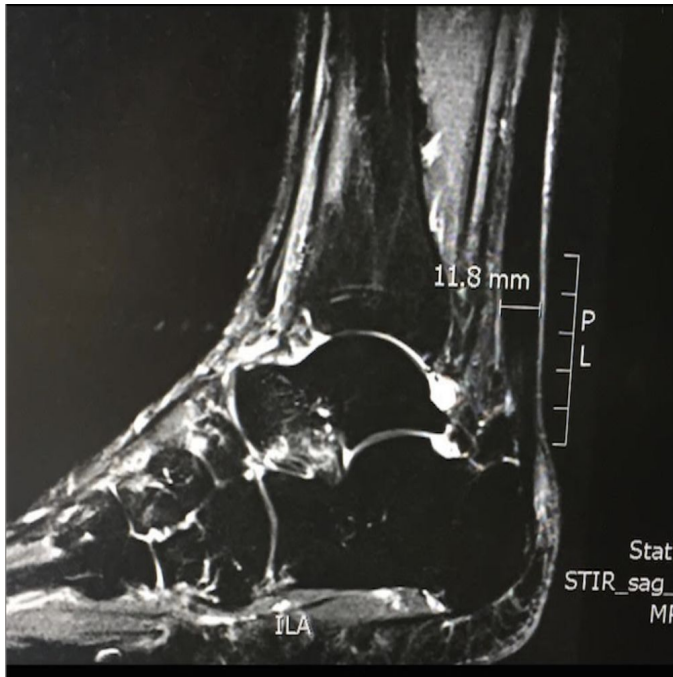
Sagittal view MRI showing Achilles tendon thickness of 11.8mm.
